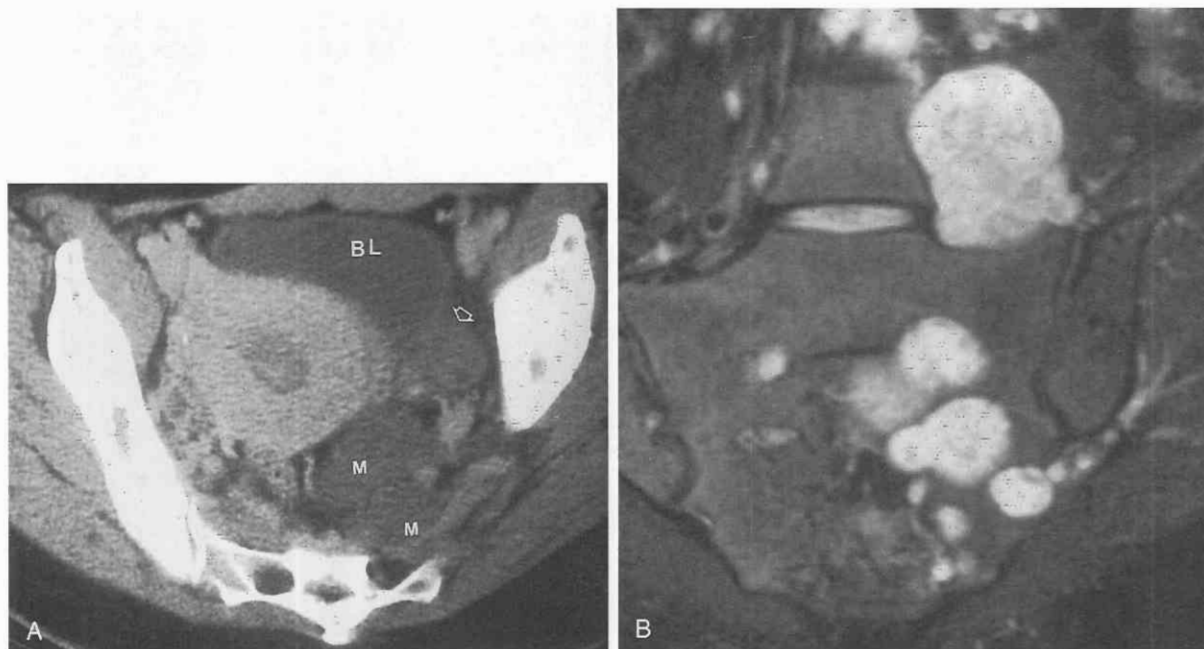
Neurofibromatosis. A, CT scan of a 18-year-old girl shows low-attenuation masses (M) with a density less than that of myometrium and muscle in the left hemipelvis. BL, bladder. Open arrow indicates the left ovary. B, Transaxial T2-weighted fast spin-echo (TR 3000/TE 54/180 degrees) image shows high-signal-intensity neurofibromas in the left paraspinal area and involving the sacral foramen.
